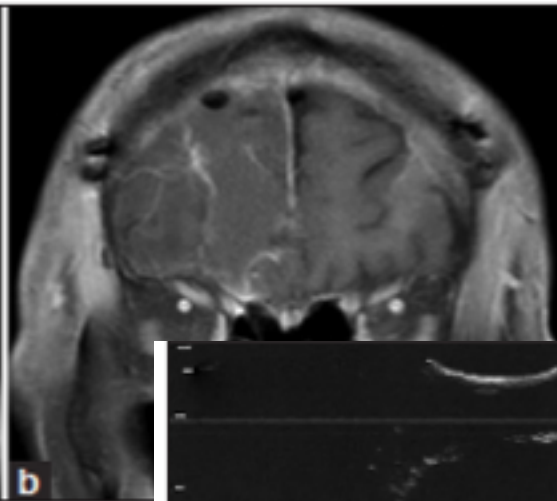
Intraoperative ultrasound photographs. (a) Before drainage
